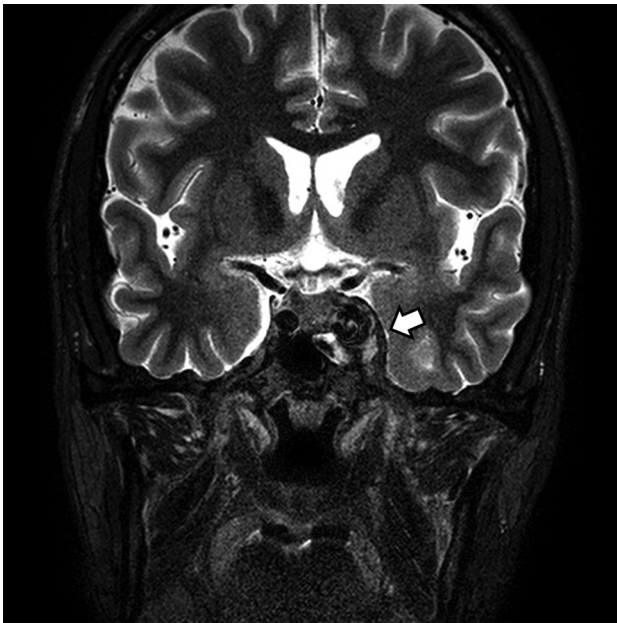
A CCF case with abnormal contour of the cavernous sinus. Coronal T2-weighted image of a patient with diplopia, confirmed to be left sixth cranial nerve palsy on neurologic examination. Note the abnormal contour bulging of the left cavernous sinus (*arrow*). An internal signal void was also noted on both T2-weighted (*arrow*) and T1-weighted imaging (not shown). The patient was confirmed as having a direct CCF on digital subtraction angiography.
